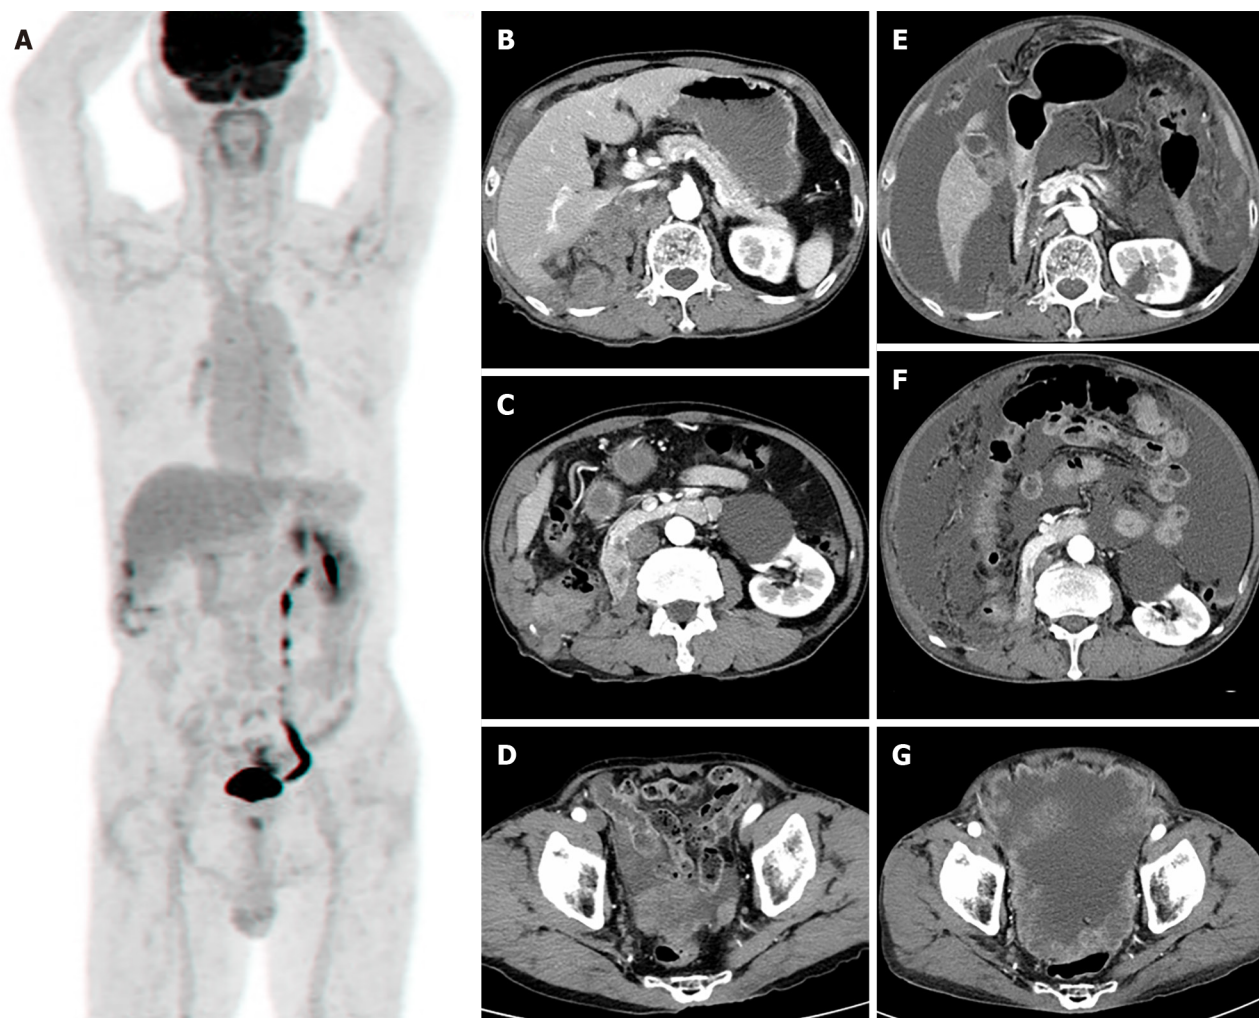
Immediate post-operative ^{18}F -fluorodeoxyglucose torso positron emission tomography scan and follow up abdominal computed tomography. A: ^{18}F -fluorodeoxyglucose (FDG) torso positron emission tomography after right nephrectomy shows mild FDG uptake at operation site, which suggested postoperative changes. No other abnormal FDG uptake was demonstrated; B-D: Abdominal computed tomography (CT), taken 6 months after right nephrectomy, shows local recurrence and peritoneal metastasis; E-G: Abdominal CT scan, taken 8 months after right nephrectomy, shows locally controlled local recurrence result from radiotherapy but more progression of peritoneal metastasis with increased malignant ascites.
